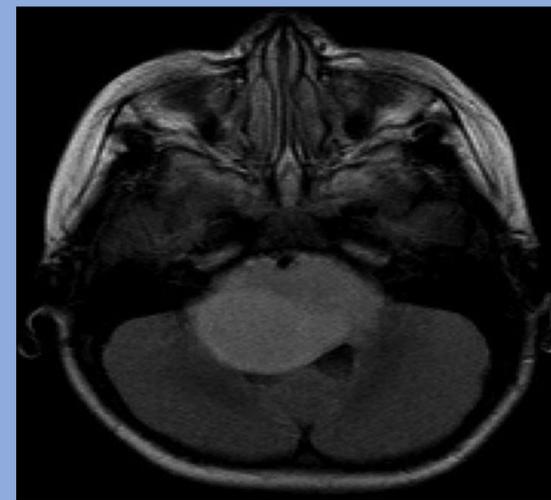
MRI Axial View of hyperintense tumor of the pons and brachium pontis.⁷
